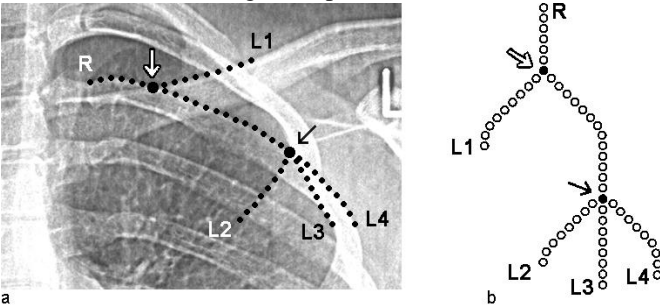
Multiple-path branching, in which visited image pixels become vertices in a tree graph. (a) A close-up of a chest radiograph showing progress of the multiple-path edge-following after 55 visited pixels. (b) The associated tree graph T . The white arrow shows the first ambiguous pixel encountered whereas the black arrow shows the second one. Letters point out special vertices. “R” stands for “Root” and “L” for “leaf”.
